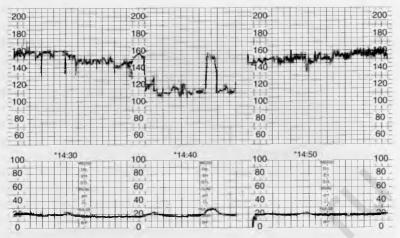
Recording by ultrasound – initial recording is that of the fetus. The ultrasound transducer slipped to the flank and picked up the maternal heart rate. This was identified and the transducer was replaced to record the fetal heart rate.
